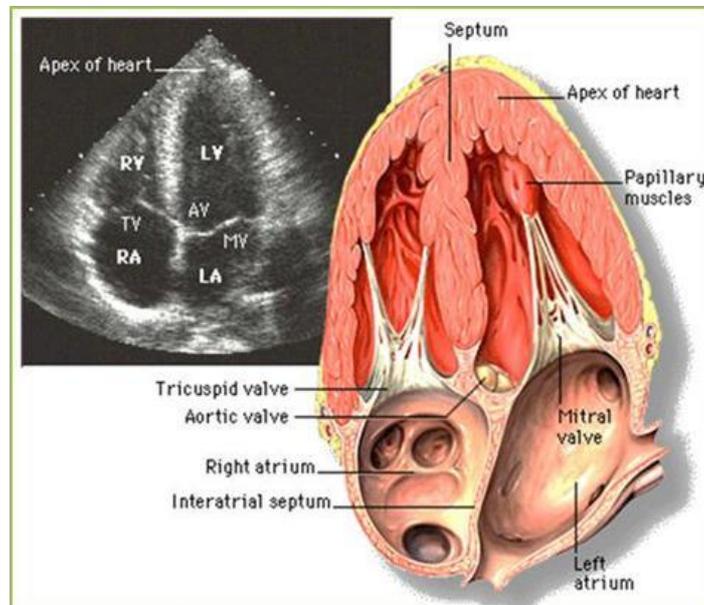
Apical four chamber view with transthoracic echocardiography
